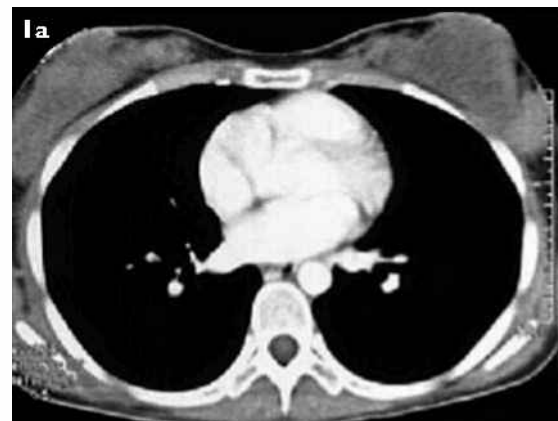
Axial CT images show (a) diffuse infiltration of the breasts with nodular lesions, and (b) masses in the ovaries (right, 4 cm × 3 cm; left, 6 cm × 5 cm).
